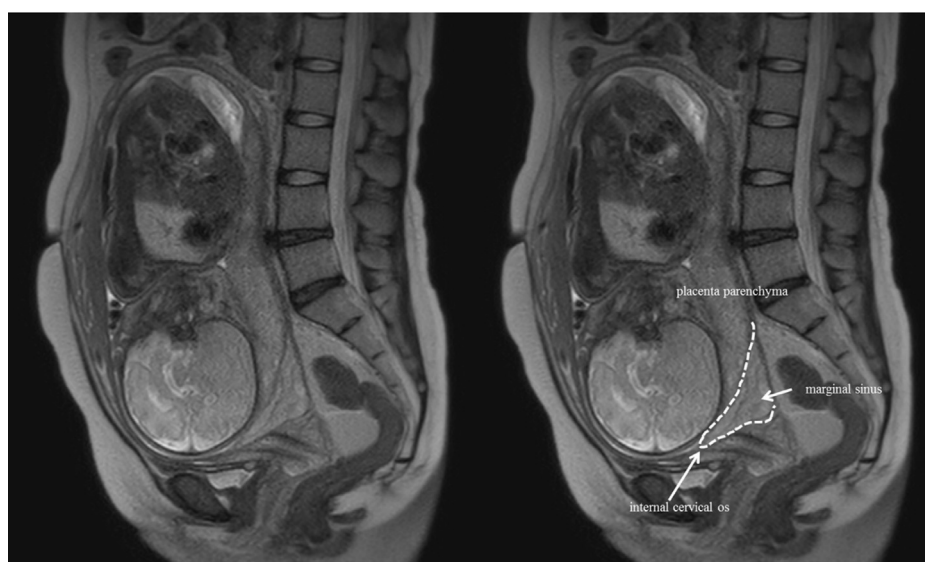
Representative MRI images of marginal sinus placenta previa.
